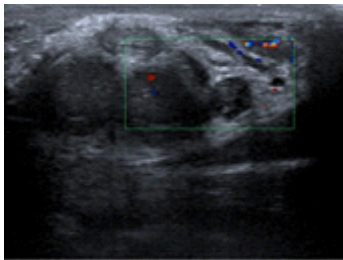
Doppler Ultrasound showing thrombosed left spermatic vein with no flow.
